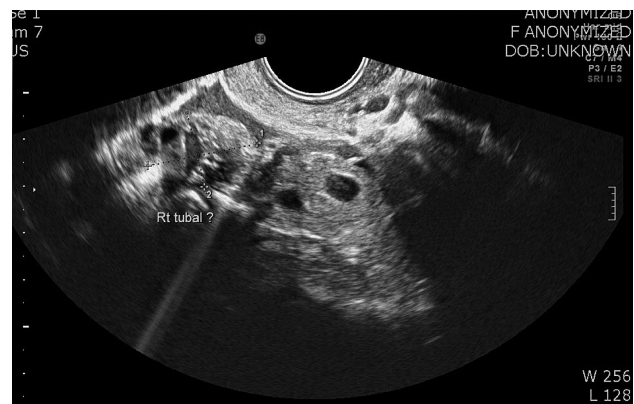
Ultrasonography showing a right tubal complex cystic lesion and normal ovary.
